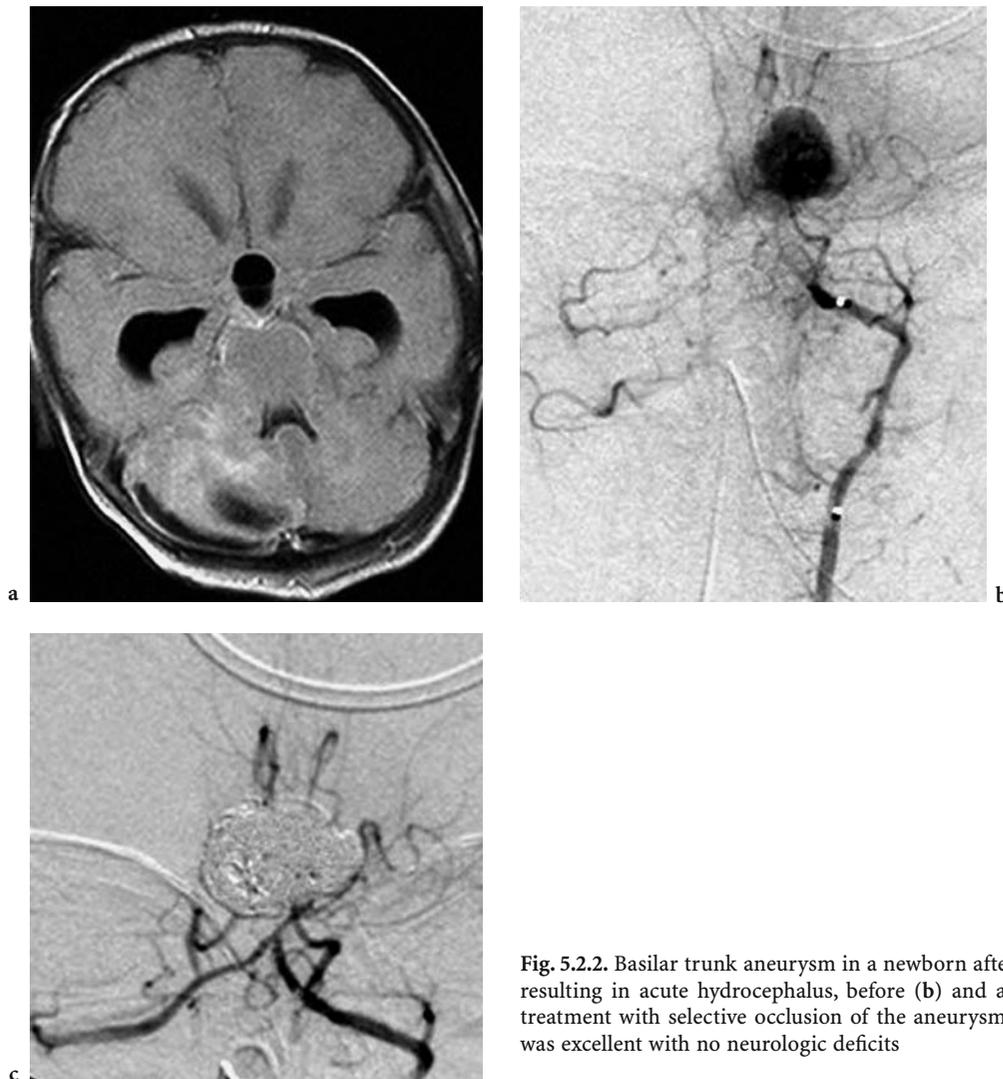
Basilar trunk aneurysm in a newborn after bleeding (a, FLAIR) resulting in acute hydrocephalus, before (b) and after (c) endovascular treatment with selective occlusion of the aneurysm. The baby's outcome was excellent with no neurologic deficits
